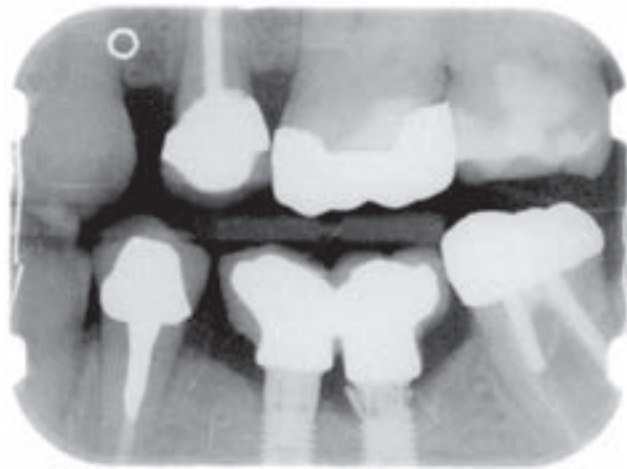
Radiographic image of a fractured internal connection implant. The implant fractured through internal hoop stresses generated by occlusal loading of the implant-supported crown. The presence of a splinted second implant and sound adjacent teeth did not prevent this catastrophic failure. It is likely that internal connection implants will be shown to be susceptible to hoop stress failure as the time from loading increases. Fatigue failure of metals is time dependent.
